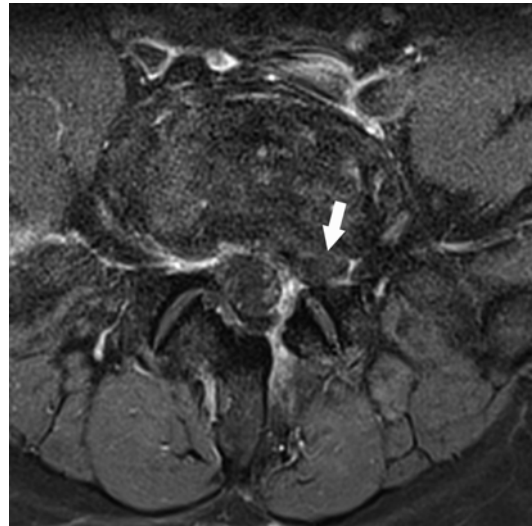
Persistent radicular pain after diskal surgery. Axial gadolinium-enhanced T1w MR image shows a non-enhancing mass within foramina consistent with hernia recurrence (*arrow*)
